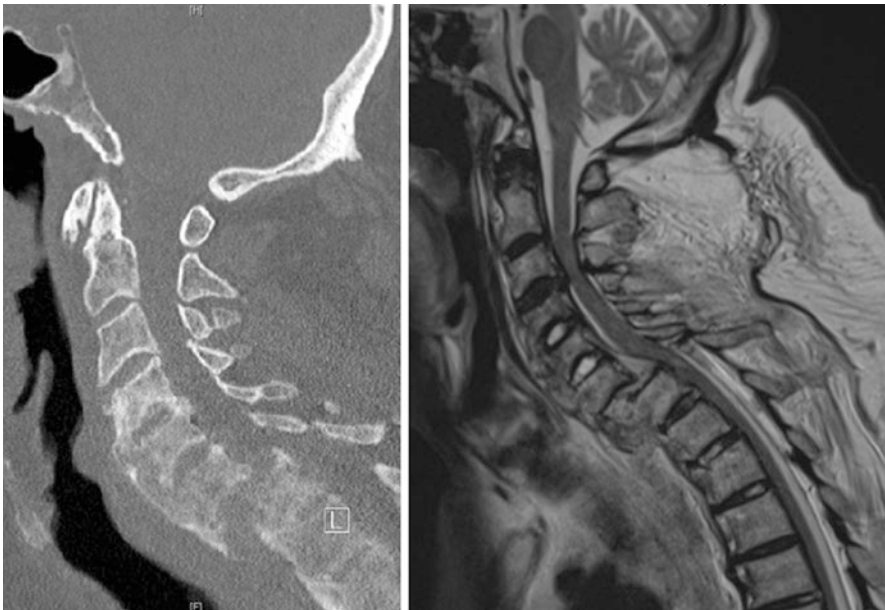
CT and MRI of a displaced C6-C7 fracture in DISH showing spinal cord compromise
